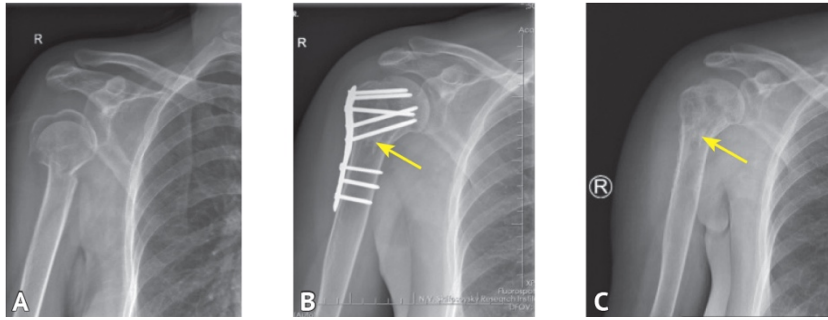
Radiographs of the right shoulder joint. A — 3-fragment fracture of the proximal metaepiphysis of the right humerus; B — one year after plate osteosynthesis with allograft augmentation (the arrow indicates the residue cortical layer of the graft); C — after removing the plate (one year after the operation). The arrow indicates the residue of the graft cortex
